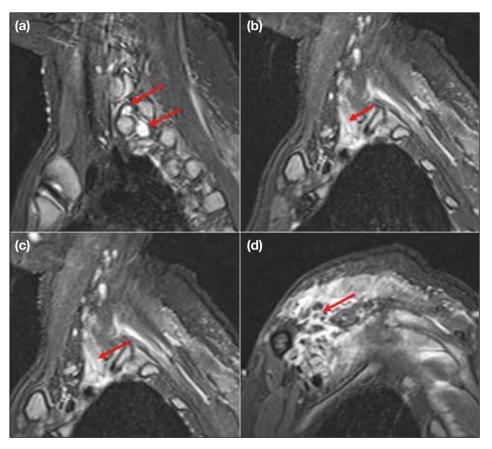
T2-weighted turbo spin echo sagittal magnetic resonance imaging of left brachial plexus with fat suppression (repetition time: 7550 ms, echo time: 85 ms): At the nerve root level (f), there were T2-weighted hyperintense cystic signals at C7/T1 and T1/T2 levels, in keeping with pseudomeningocele. The trunks (g) were replaced by diffuse high T2-weighted signal and cystic change (red arrow), suggestive of high-grade injury. Thickened divisions (h) and cords (i) with high T2-weighted signals (red arrows) were in keeping with traction injury.
